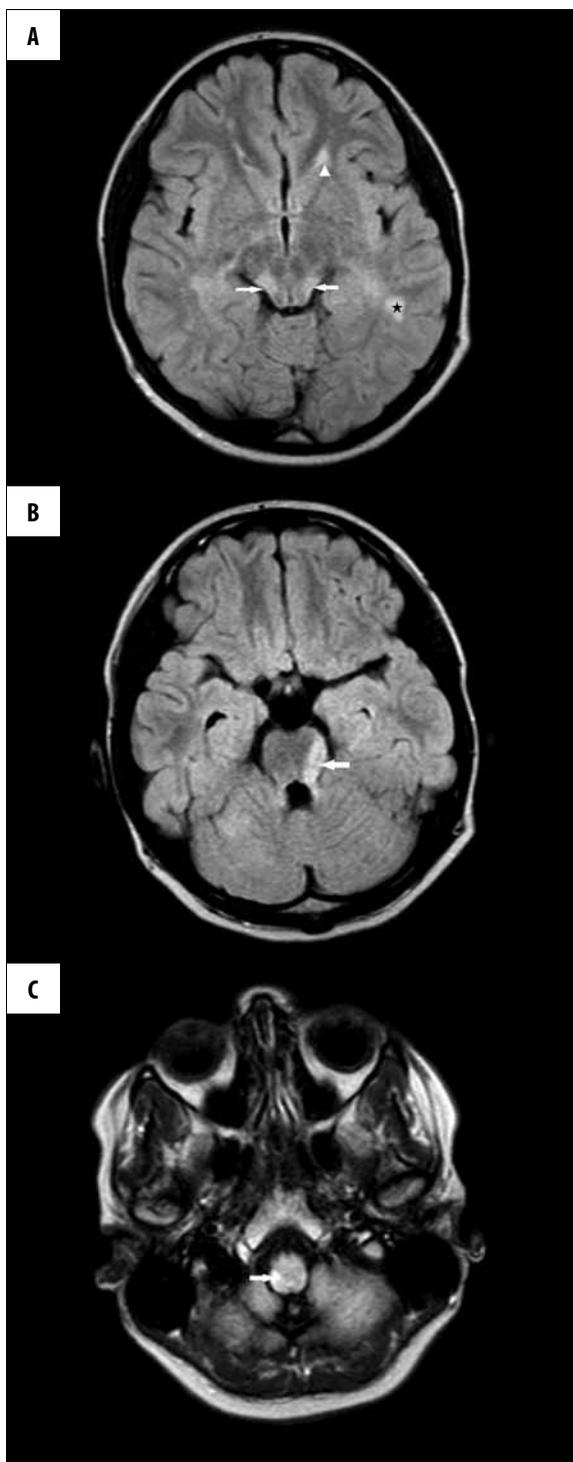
16-year-old girl, MRI brain scan, FLAIR FSE sequences images, transverse plane. Demyelinating foci in: (A) cerebral peduncle (arrows), circumventricular white matter (arrow head) and in subcortical location (star), (B) a demyelinating foci in the pons (arrow), (C) a demyelinating focus in medulla oblongata (arrow).
